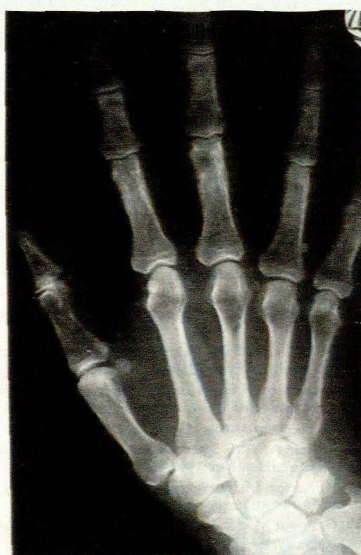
Radiograph of the left hand showing subperiosteal resorption and lesions compatible with brown tumours involving the third metacarpal and proximal phalanx, and the proximal phalanx of the thumb.
